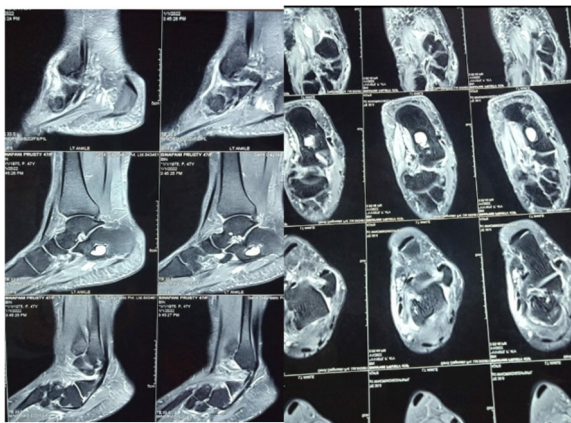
MRI study of the Left ankle; small calcaneal lipoma (measuring ~ 1.7*1.2*1.0 cm).
